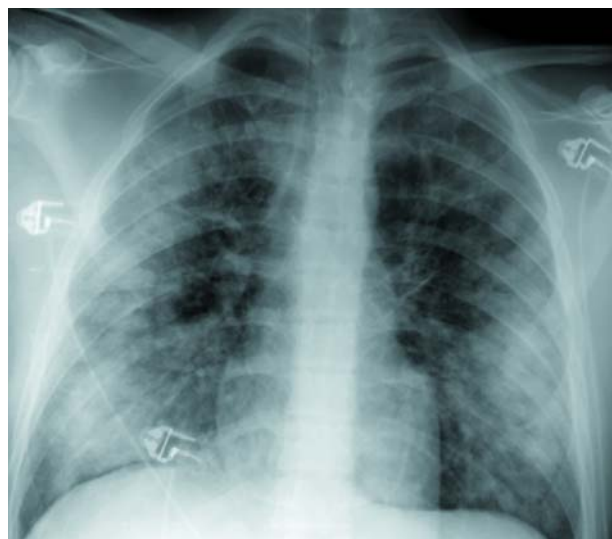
Chest radiograph in strongyloides hyperinfection
